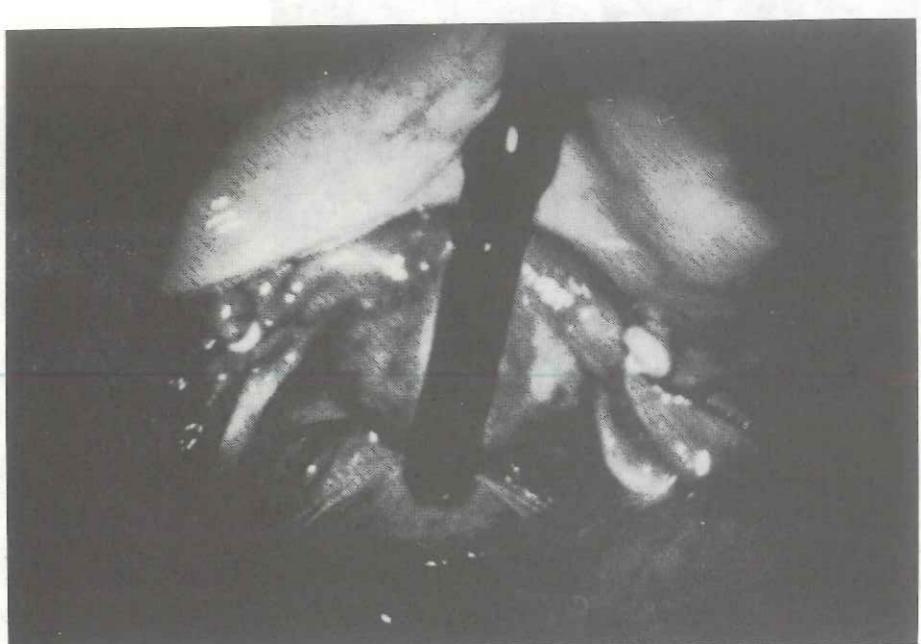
Ultrasonic probe in contact of the uterus.
